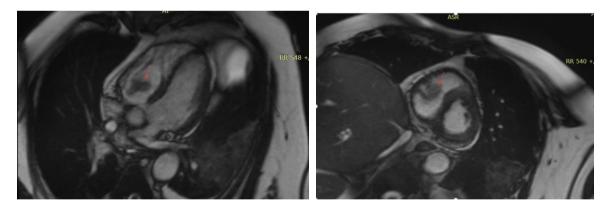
Cardiac MRI showing a peri-tricuspid valvular mass suggestive of a thrombus
